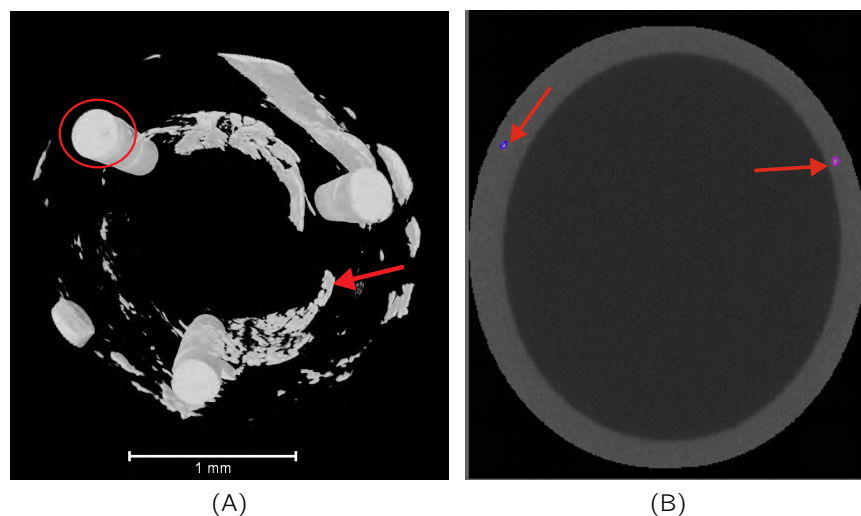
Segmentation editor from P32 and micro-computed tomograph from P29 subcutaneous CVC section showing the radiopaque 'substances'. (A) showing radiopaque columns circled in red and the biofilm containing deposit indicated by a red arrow and (B) segmentation editor image highlighting radiopaque clusters in purple and blue (red arrows) within the CVC wall.
